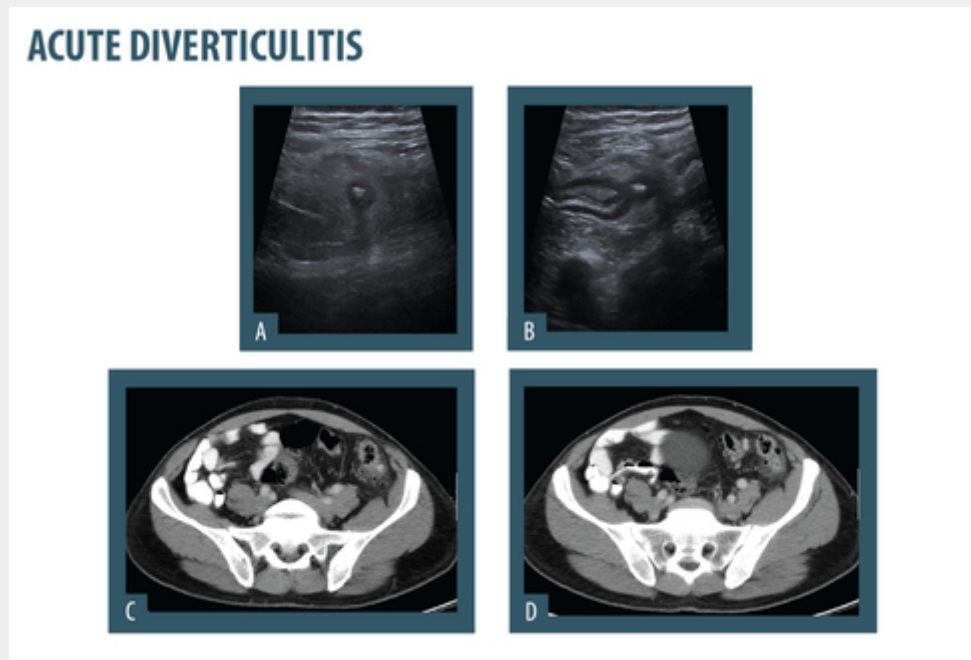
63 year-old patient presenting with acute lower quadrant pain. On US (A,B) there is apparent thickening of the bowel wall, which was also aperistaltic. There seems to be some pericolonic fluid. On CT (C,D) there are some air filled "finger-like" projections on the sigmoid wall, suggestive of diverticula. There is enhancement of the mucosal wall, compatible with inflammation.
